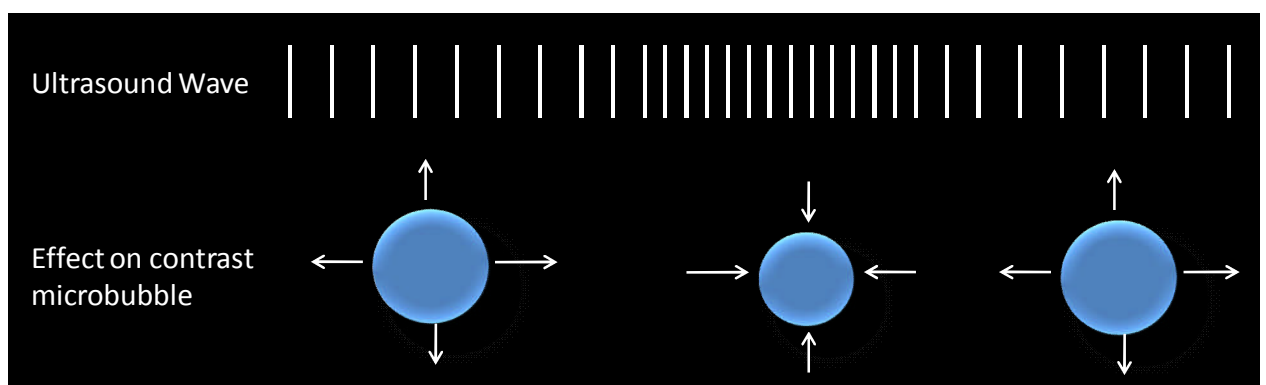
Mechanism of action of ultrasound contrast agents
